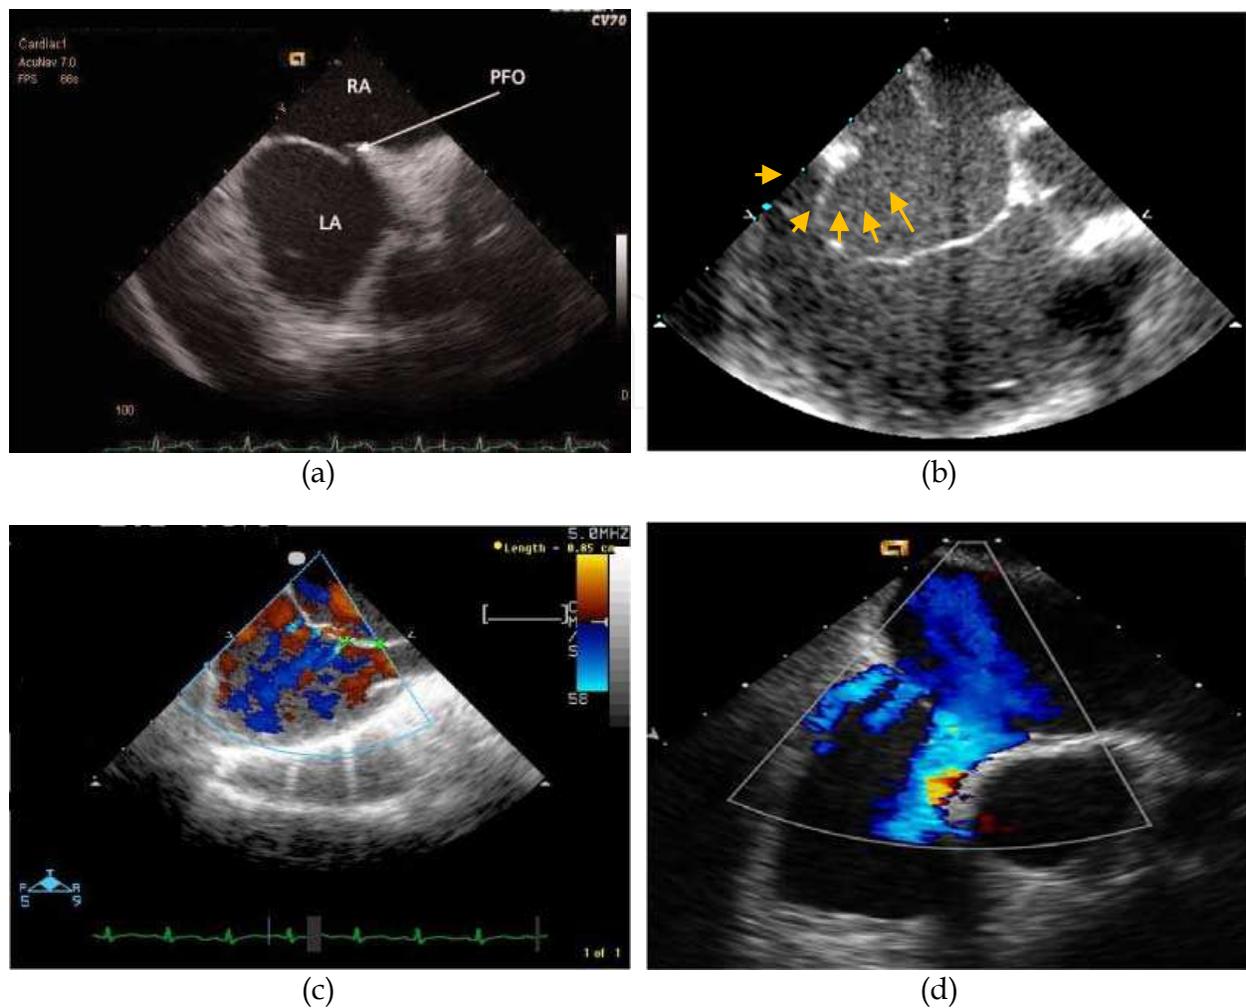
Echocardiographic appearance of different PFO morphologies, a: Intra Cardiac Echo (ICE) of a tunnel shape PFO. b: Large atrial aneurysm (orange arrow heads) by trans thoracic echo (TTE). c: small multi fenestration by TTE color Doppler. d: larger fenestrations by TEE color Doppler.
